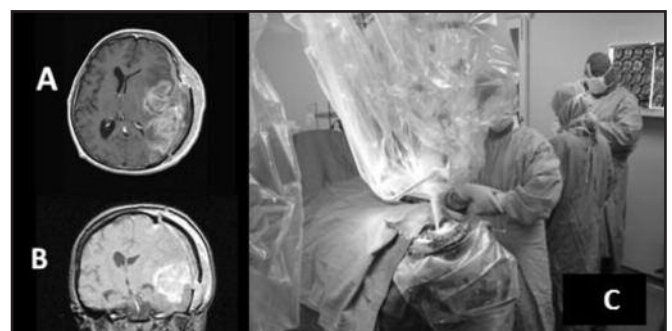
A and B: Axial and coronal slices of MRI brain show left frontotemporal high grade gliomas. C: An intraoperative radiation therapy procedure.
